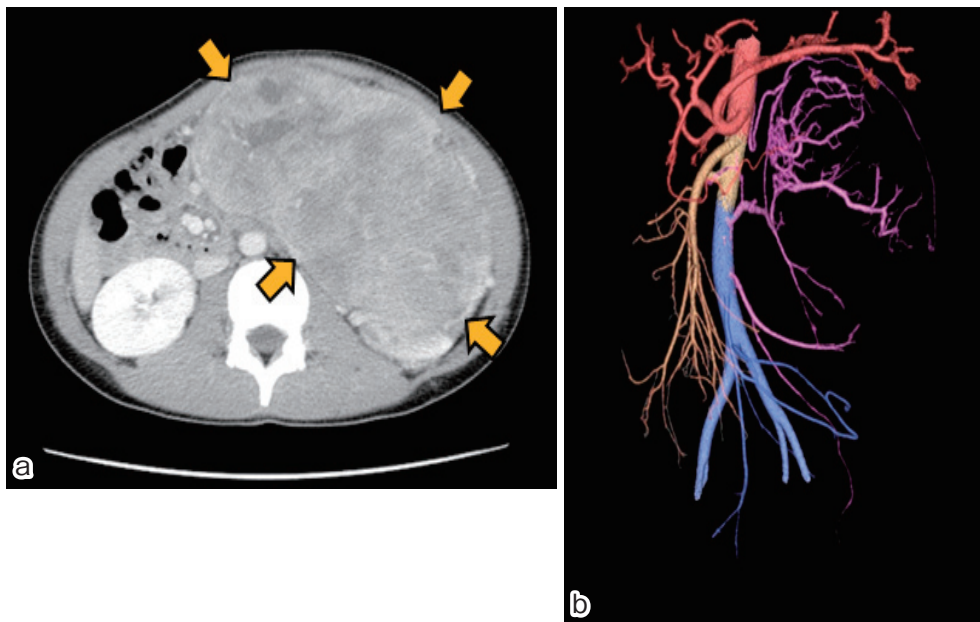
(a) Contrast-enhanced computed tomography (CT) image at diagnosis. A large tumor in the left kidney is indicated by the arrow. (b) Three-dimensional CT image at diagnosis. The tumor is fed mainly by the ascending branch from the celiac artery, the middle branch from the left renal artery, and the descending branch from the inferior mesenteric artery.
